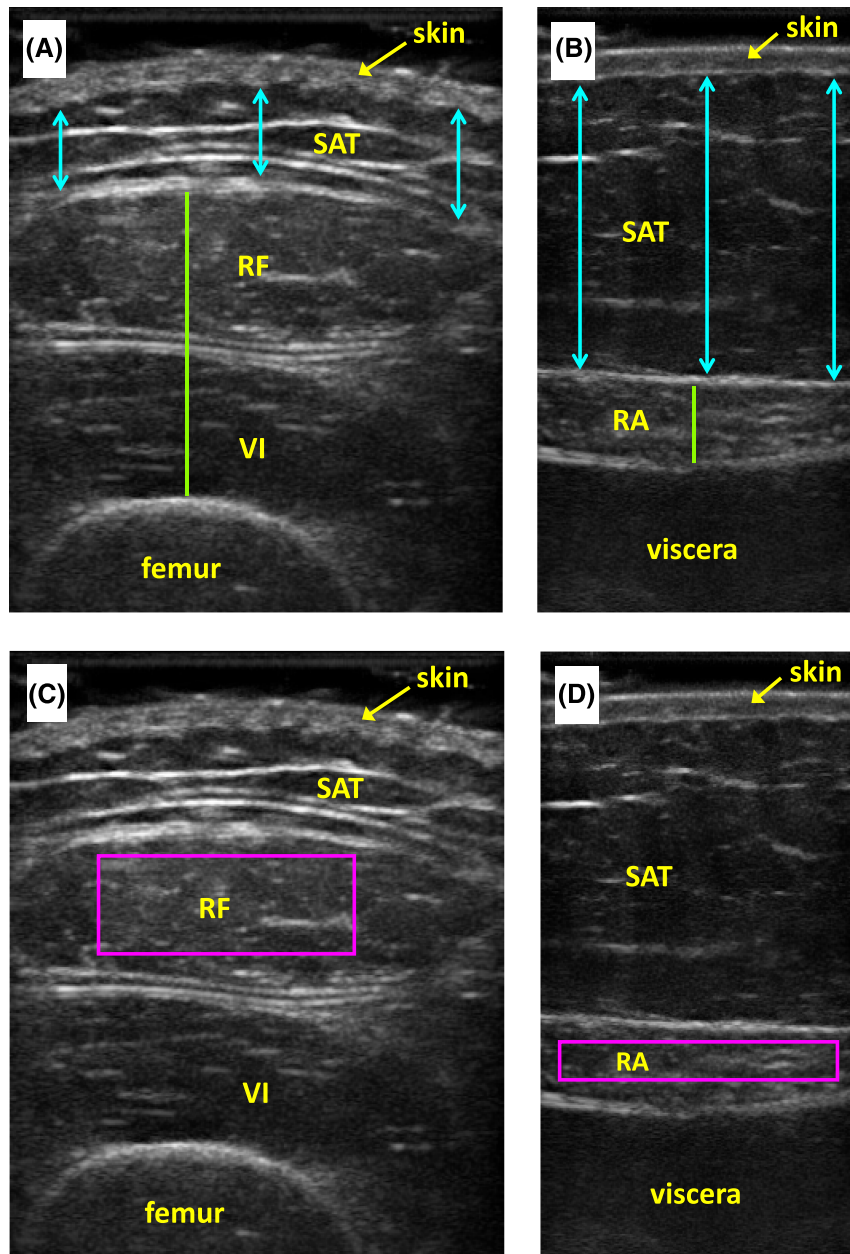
Placement of ImageJ measurement tools for ultrasound thickness (A, B) and muscle quality (C, D) analysis. Green lines indicate where anterior thigh and abdominal muscle thickness measurements were made; blue arrows indicate where anterior thigh and abdominal SAT thickness measurements were made. Purple boxes indicate the ROI where anterior thigh (rectus femoris) and abdominal (rectus abdominis) muscle quality was evaluated. RA, rectus abdominis; RF, rectus femoris; ROI, region of interest; SAT, subcutaneous adipose tissue; VI, vastus intermedius.
